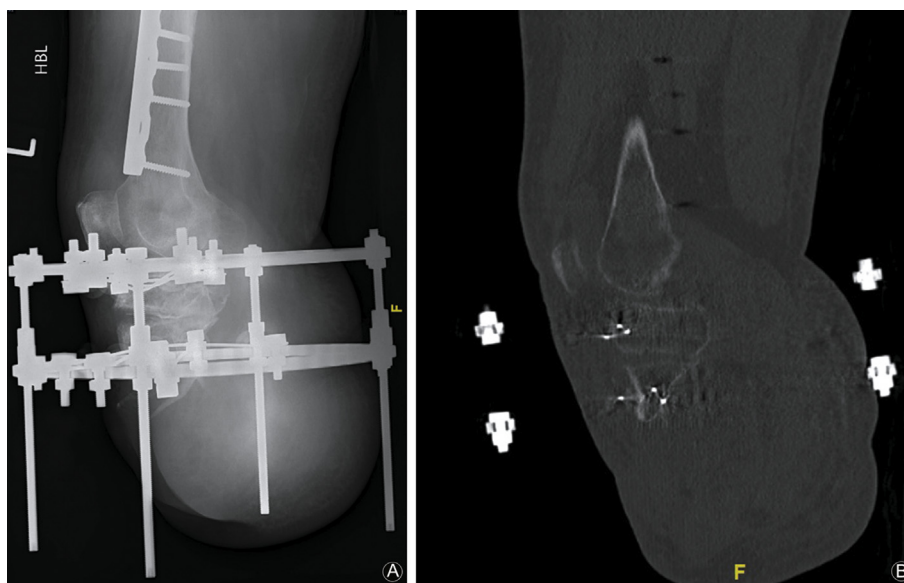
Radiographs (A) and CT scan (B) showing premature consolidation of the posterior cortex.
